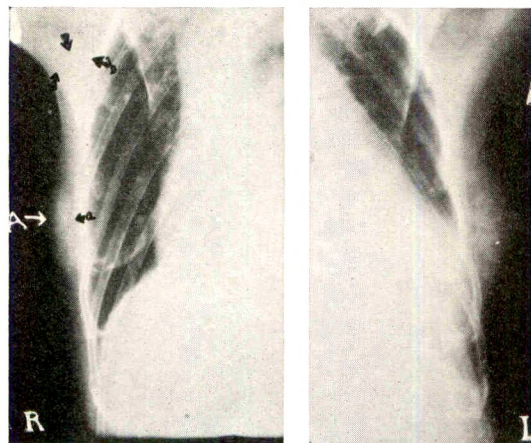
Same case as in Figure 20 nine months later, showing the atrophy of left breast with the general loss of weight. Right breast, showing shrinkage of (a) original tumor, and (b) axillary mass under roentgen therapy. The patient died with a silent metastasis in the brain. Autopsy showed atrophic carcinoma cells in masses of scars in the breast.
